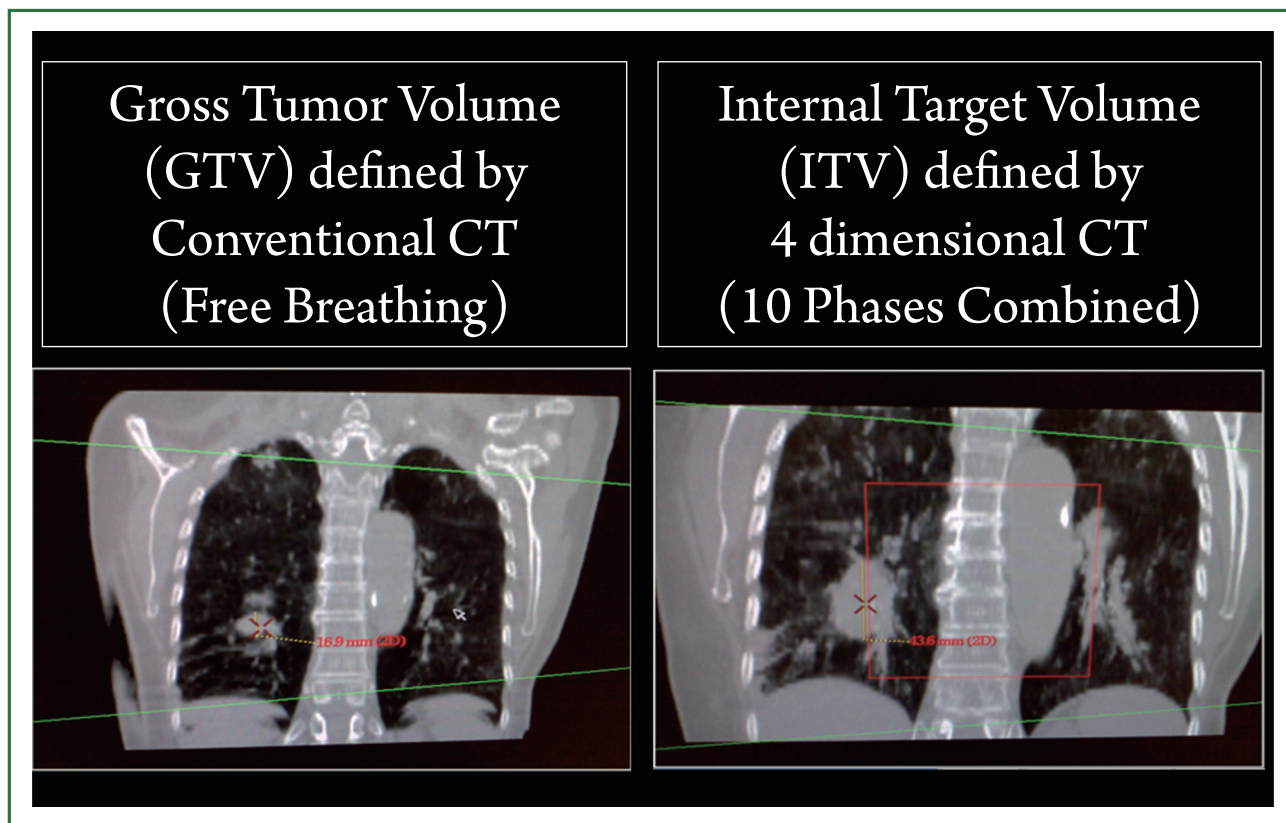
Four-dimensional CT (4D-CT) reduces motion artifact and allows accurate determination of internal target volume (ITV) for small-sized pulmonary tumors.
